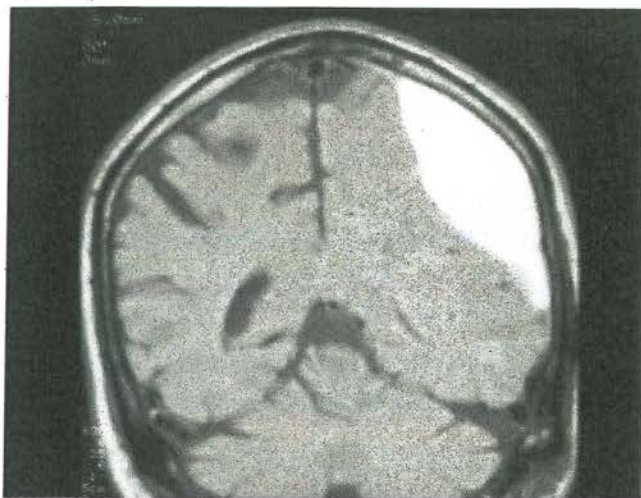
Coronal T1-weighted MRI scan showing a subdural haematoma
